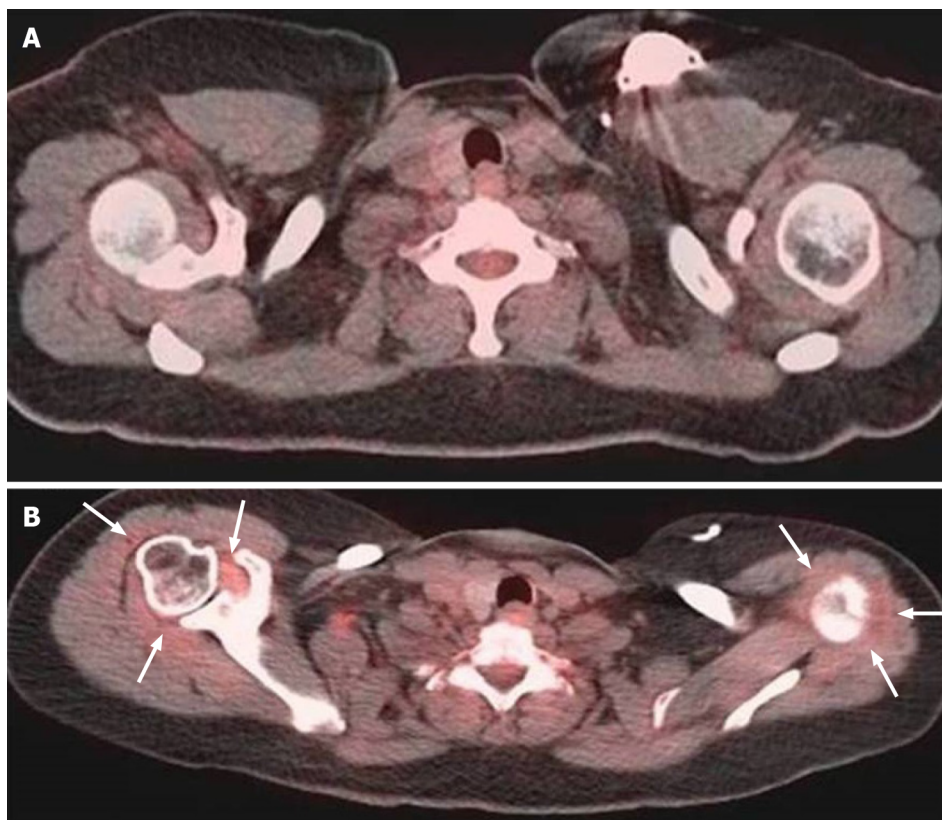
Fifty-two years old patient with lung cancer. A: Initial pre-therapy Positron emission tomography - computed tomography showed no significant capsular 18F-fluorodeoxyglucose (FDG) uptake; B: After the patient was treated with chemotherapy for his lung cancer, the patient developed bilateral shoulder pain with bilateral capsular FDG uptake.
